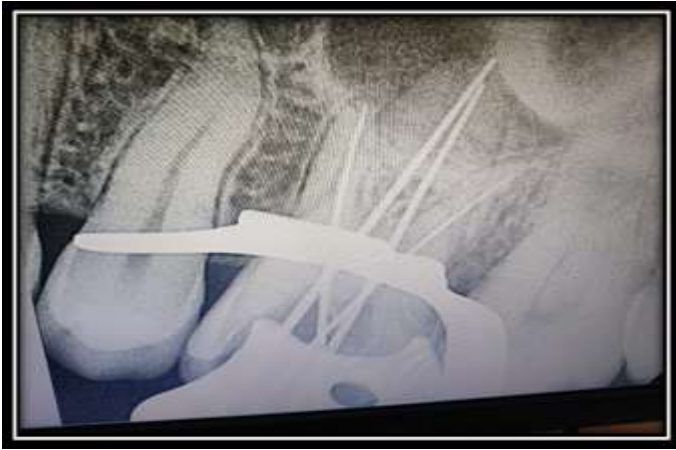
Periapical radiograph showing working length
